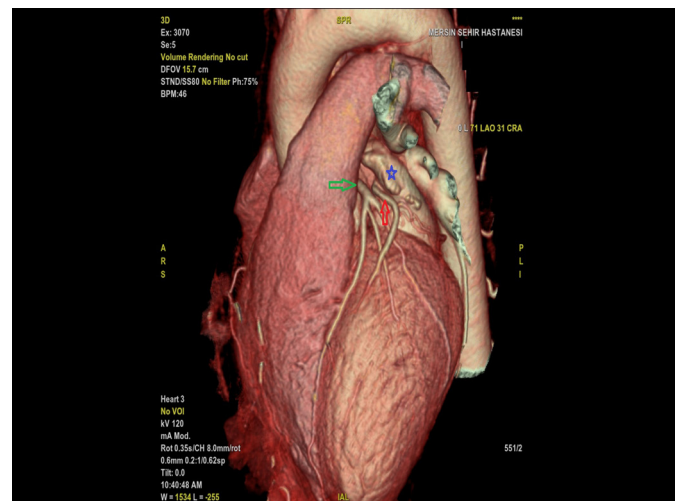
Case 1. Three-dimensional volume-rendered CT image. Blue star: LAA; red arrow: GCV; green arrow: left main coronary artery. The GCV terminates directly in the LAA
